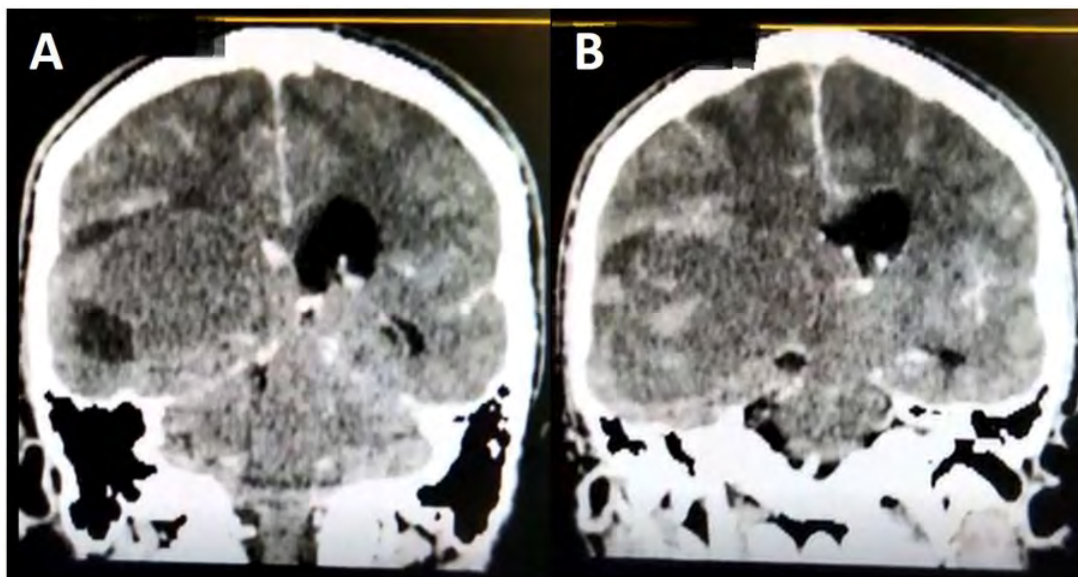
A, B. Pre-operative CT. Coronal view.
